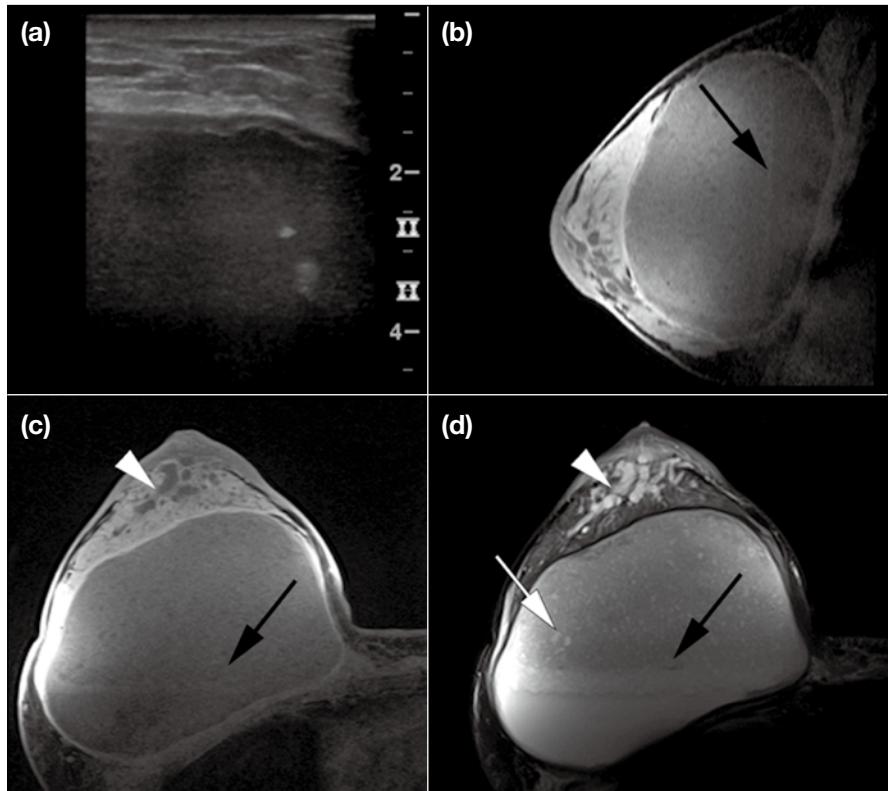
A 34-year-old lactating mother, with a history of breast augmentation by injection, presenting with engorgement, erythema, and tenderness of bilateral breasts. (a) Transverse ultrasound image, (b) sagittal and (c) axial T1-weighted gradient echo magnetic resonance imaging (MRI) with fat saturation and (d) T2-weighted turbo spin echo MRI with fat saturation. Huge retroglandular fluid collection is seen in the right breast. On ultrasound (a), only the superficial parts can be evaluated. On MRI, the imaging modality of choice, there is dependent layering of infected material (black arrows) and injected foreign substance (white arrow). Engorgement of ducts (white arrowheads) is seen in the retroareolar region, consistent with lactating history. The patient subsequently underwent incision and drainage of the right breast collection that yielded more than 1200 ml of purulent fluid with gelatinous debris.
